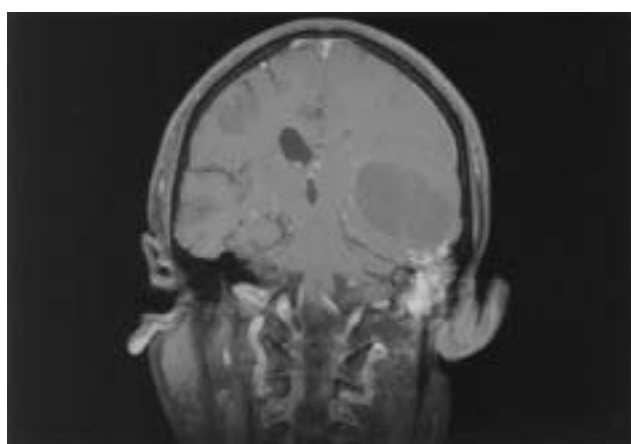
Coronal view of brain T1-weighted MRI showed the cystic lesion and osteomyelitis of temporomandibular joint.
